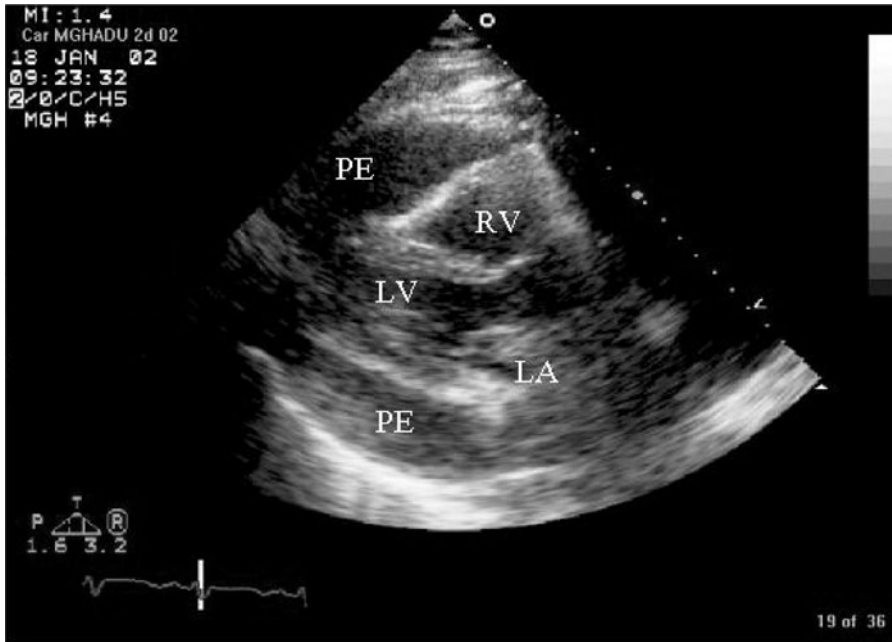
Large pericardial effusion detected on echocardiogram. LA = left atrium; LV = left ventricle; PE = pericardial effusion; RV = right ventricle.
